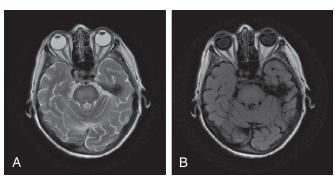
Small vessel microangiopathic changes of the pons. (A) Axial T2 and (B) axial FLAIR. Chronic microangiopathic changes involving the central pons in an asymptomatic patient. Supratentorial chronic microangiopathic changes were also seen. Note involvement of the corticospinal tracts.
